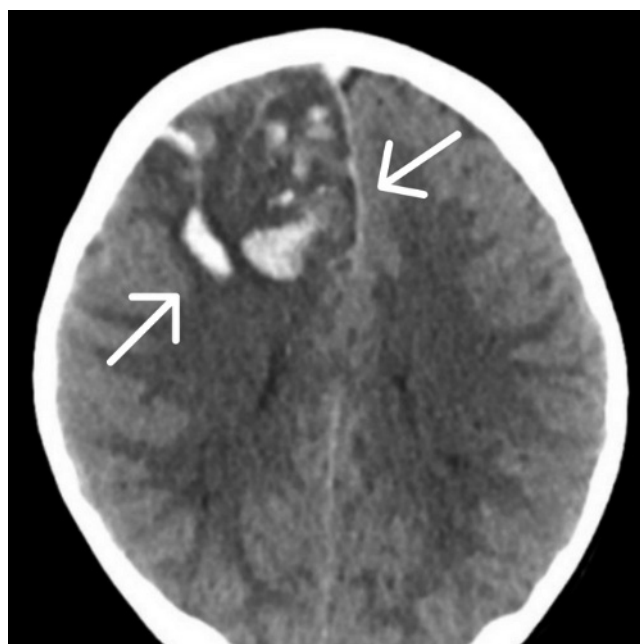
Head CT without contrast from first day of hospitalization showing foci of intracerebral haemorrhage and surrounding oedema ($54 \times 48 \times 40$ mm) in the right frontal lobe. Along the cerebral falx, features of subarachnoid haemorrhage and thrombosis of the superior sagittal sinus are visualised. There was a mass effect – the median line shifted by 6mm to the left side
